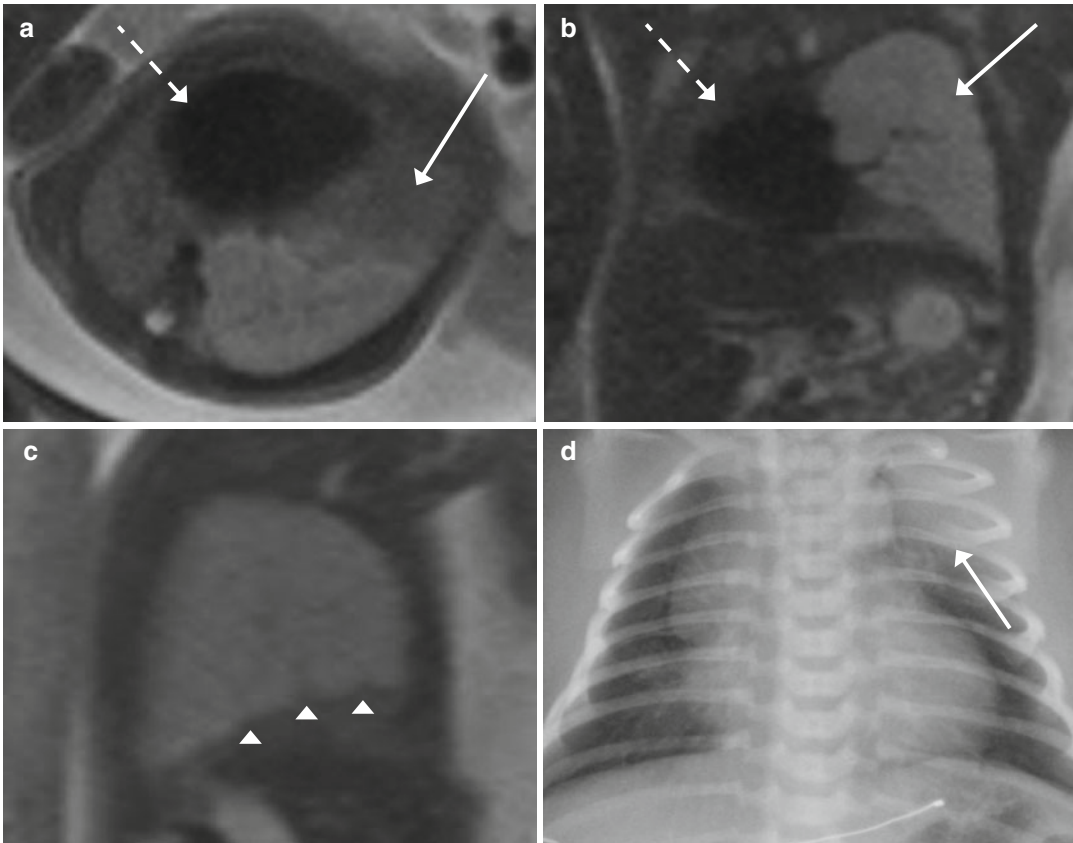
CPAM of type III (GW 23+4); an isolated dextrocardia was described at the US screening of the second trimester. (a–c) Axial (a), coronal (b), and sagittal (c) T2-weighted images (TR/TE ∞ /95 ms): the lesion is recognizable as hyperintensity of left superior pulmonary lobe (*arrow*, b), in comparison to the adjacent normal parenchyma (*arrow*, a), with scissural delimitation
